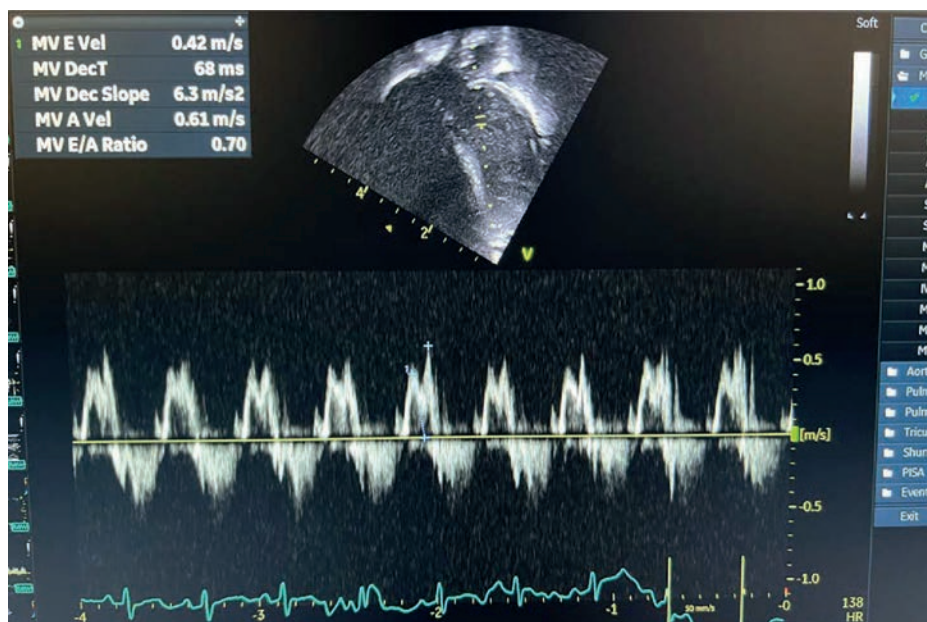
Apical 4 Ch view trans-mitral flow
